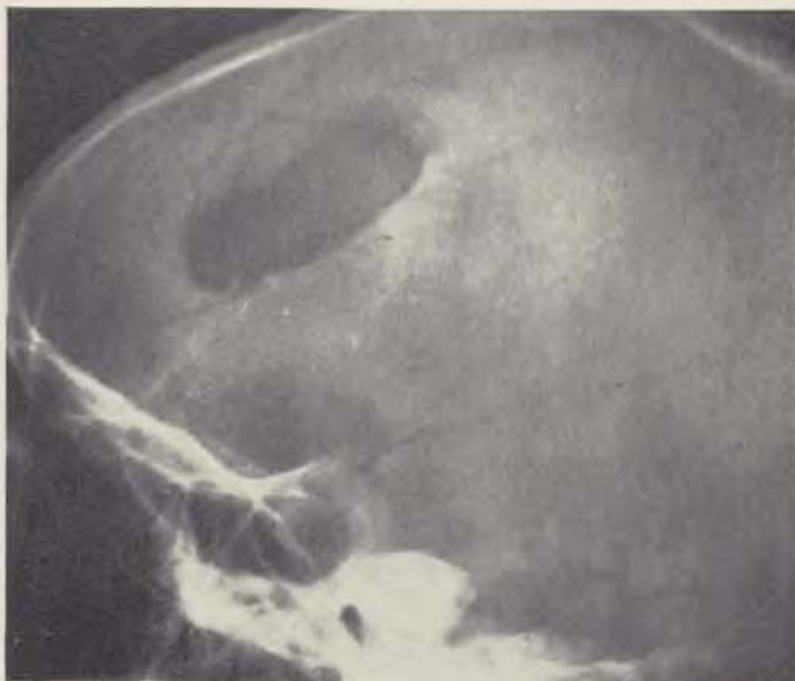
The same patient. X-ray of the skull after operation.
